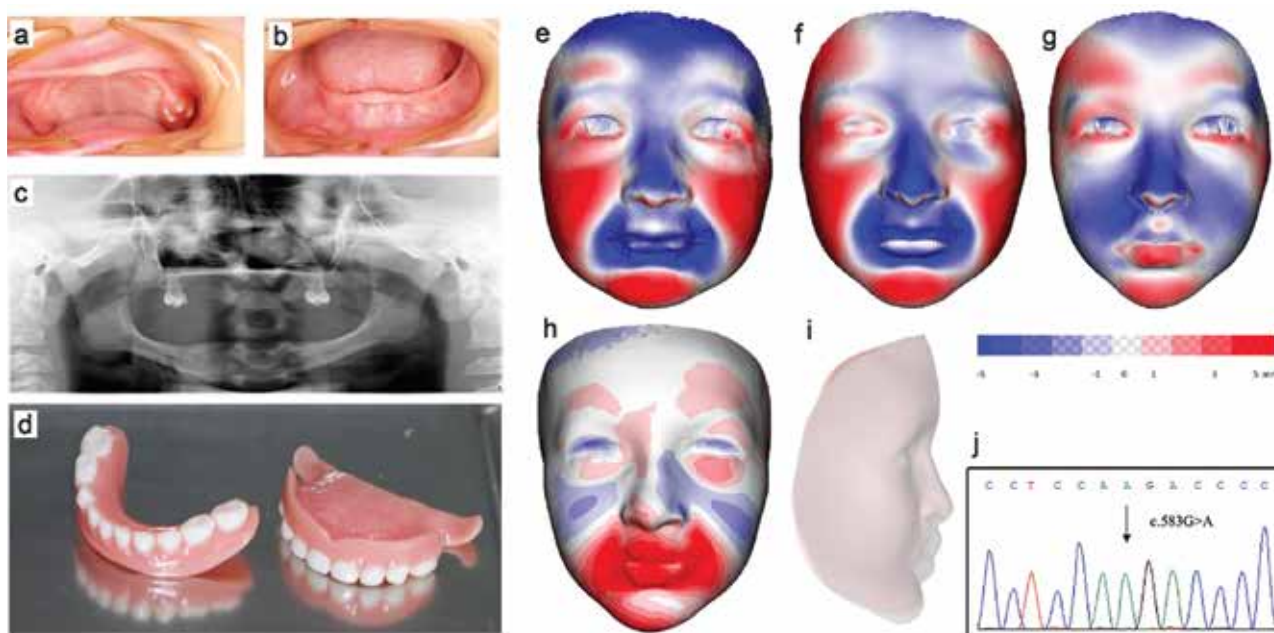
Case 1: Intraoral photograph of the upper and lower jaw at the age of 3 years (a, b); OPG X-ray at the age of 5 years (c); Upper and lower partial dentures at the age of 5 years (d). 3D Facial scans (e–i): 3-year old vs. normal (e); 5 years old vs. normal (red protrusion/blue retrusion according to color intensity) (f); 5-year old with dentures vs. normal (g); 5 years old with and without dentures (h) 5-year-old with and without dentures (profile), and j) Single nucleotide substitution in the EDA gene leading to X-linked hypohidrotic ED.
